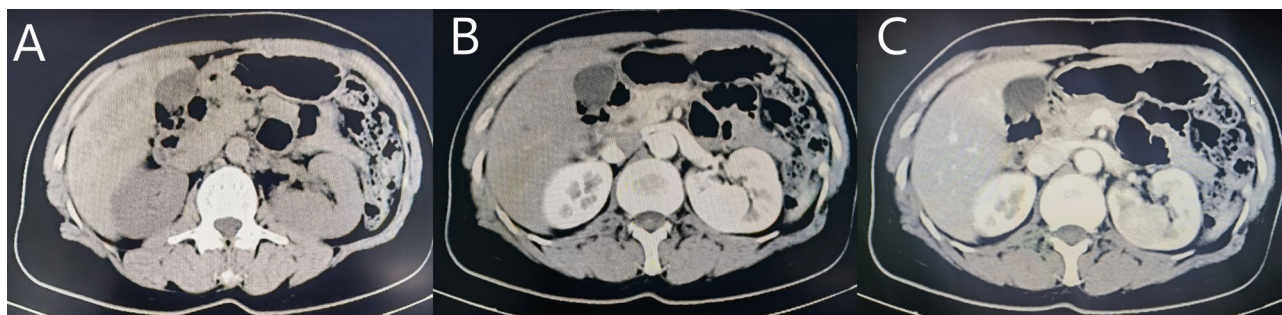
Abdominal enhanced CT. (A) Abdominal plain CT. (B) arterial phase of enhanced CT. (C) venous phase of enhanced CT
